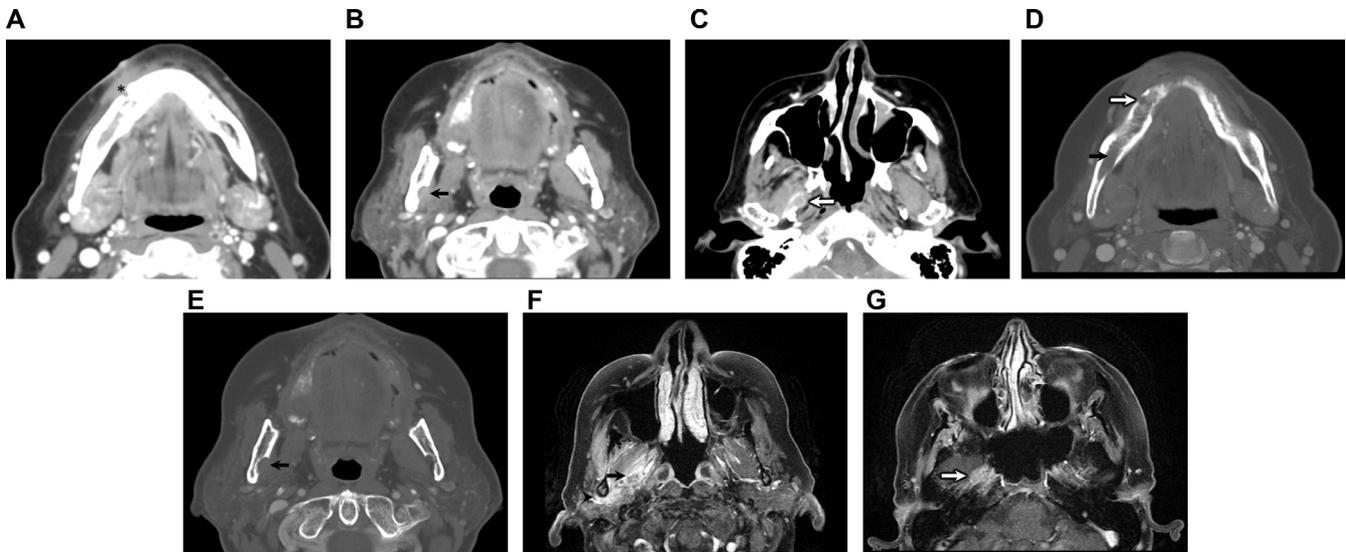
Intracranial perineural spread of tumor along V3 branches from a biopsy proven right mandibular alveolar squamous cell carcinoma. (A) Axial contrast-enhanced CT in soft tissue (A-C) and bone windows (D, E). There is abnormal soft tissue effacing the (A) right mental foramen fat pad (black asterisk), (B) the right mandibular foramen (black arrow) (C) and the juxtaforaminal fat pad surrounding right V3 (white arrow) just after it exits right foramen ovale, indicating extensive perineural spread of tumor. (D) On bone windows, associated abnormal widening of the (D) mental foramen (white arrow), inferior alveolar nerve canal (black arrow) and (E) right mandibular foramen (black arrow) is seen. (F, G) Axial T1-weighted postcontrast fat-saturated images demonstrate (F) enhancing perineural spread of tumor involving right V3 (black arrow) just after exiting foramen ovale with involvement of the thickened, enhancing right auriculotemporal nerve (black arrowhead) posterior to the right mandibular ramus. (G) Perineural spread of tumor abnormally enhances intracranially in the right foramen ovale (white arrow).
